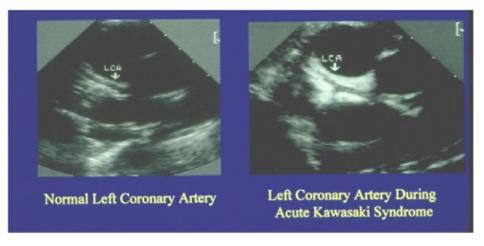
Examples of echocardiographic views of the left anterior descending artery in a modified parasternal long-axis view. Left panel: normal coronary artery with well-defined thin arterial walls. Right panel: perivascular echo brightness which obscures the arterial wall from the surrounding tissue.
